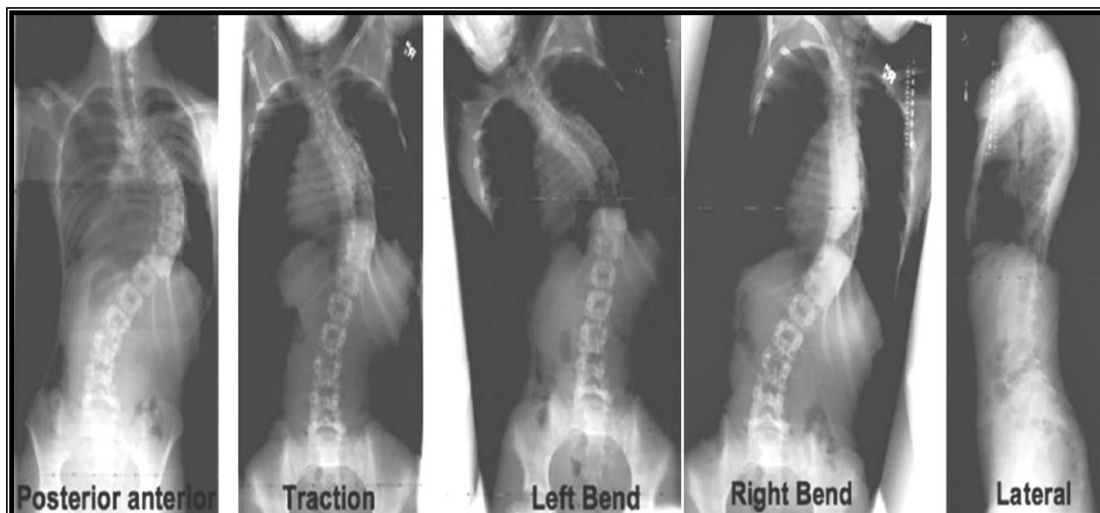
PA and Lateral radiograph (Lt) of a RT thoracic scoliosis (Rt), LT bending view (LT) and RT bending view (RT) , Note the decrease in curve degree in the Rt bending view which is the direction of the convexity [21].
